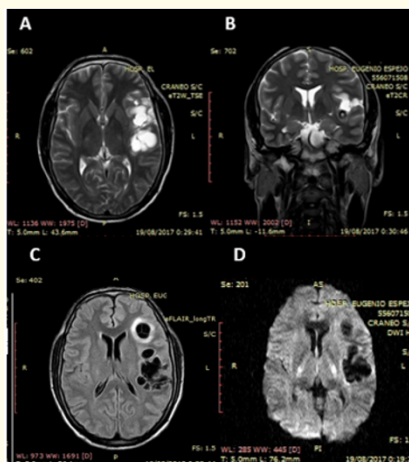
Brain MRI. A: T2, axial view; B T2, coronal view; C: FLAIR, axial view; D: DWI, axial view.
